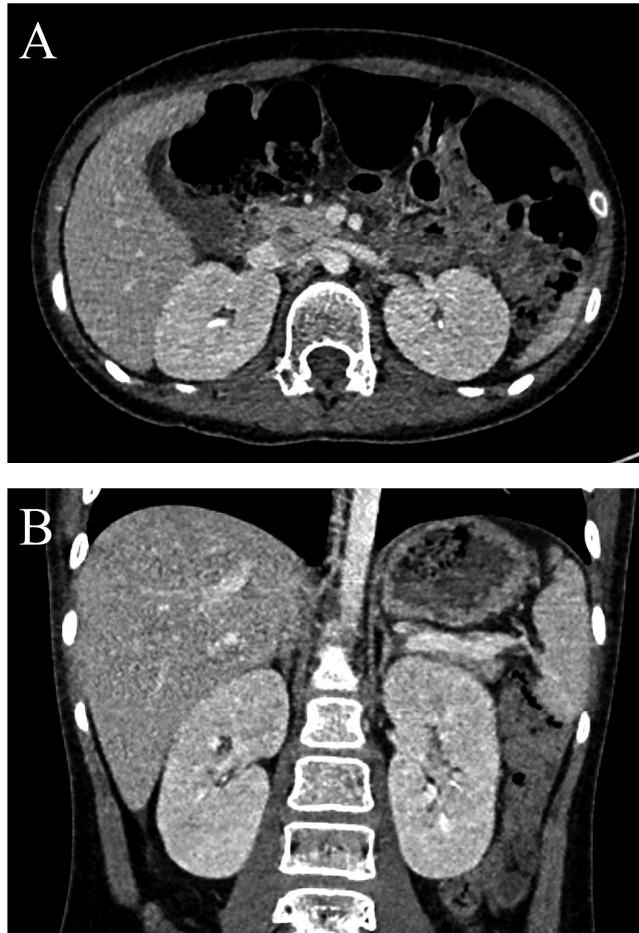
A case of false-positive diagnosis in a CT scan using the single bolus technique. This 12-year-old girl had CT scan for evaluation of the fever that developed during the adjuvant chemotherapy period after removal of brain medulloblastoma. In this CT scan, false interpretation of decreased corticomedullary differentiation of both kidneys on both axial (A) and coronal (B) images and diagnosis of diffuse renal disease was made due to delayed enhancement. Early renal excretion of the contrast is also noted. The serum creatinine level within the period between two weeks before and after the time of the CT scan was not elevated (0.35 – 0.40 mg/dL), indicating normal renal function of the patient.
